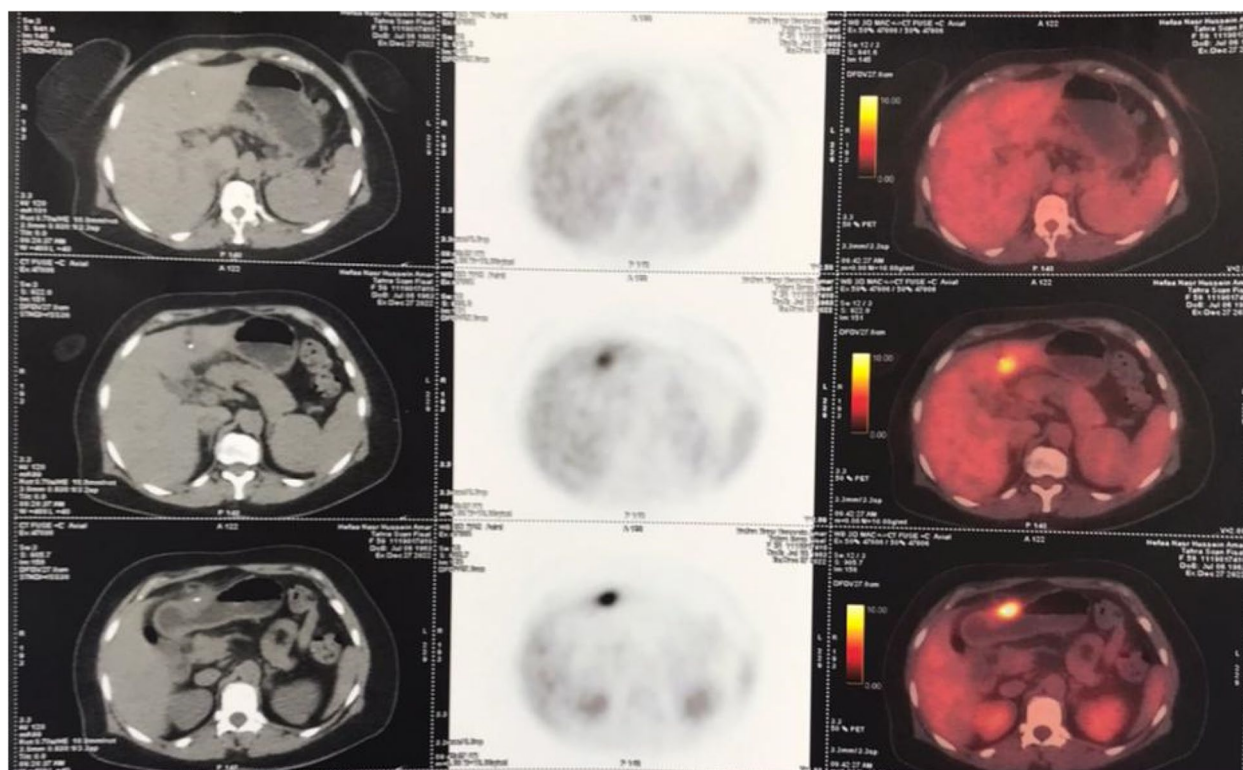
PET/CT showing irregular radiodensity in the antral lesion
